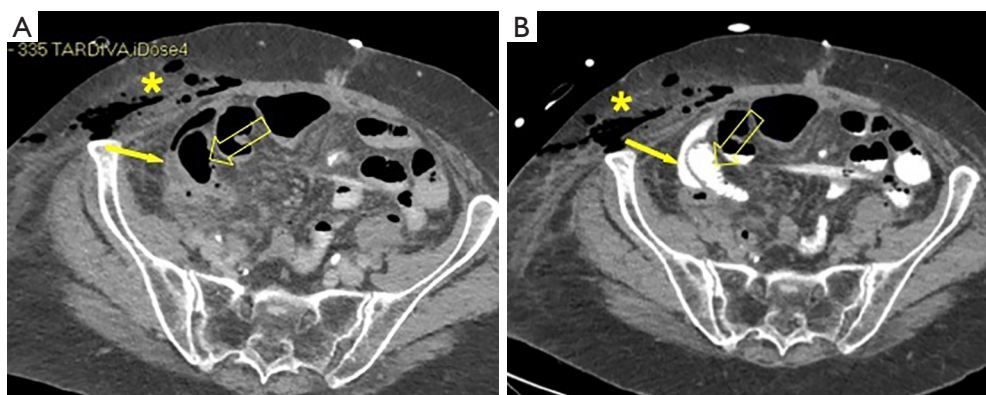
CT-scan imaging revealing the bowel perforation in case #3. (A) Small collection (filled arrow) in the right iliac fossa surrounding a tenuous loop (empty arrow). (B) Passage of contrast medium administered orally in the later phase; cellulitis and emphysema of the subcutaneous tissues of the abdominal wall (asterisk).
